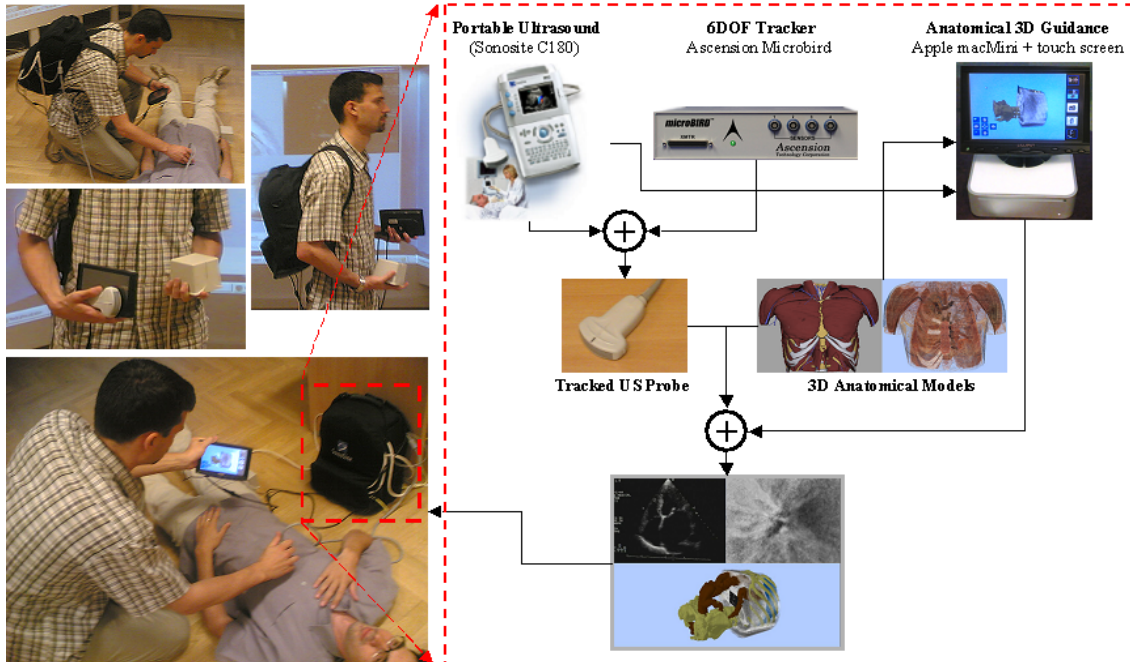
Backpack anatomically guided ultrasound system (left) system main components (right)
